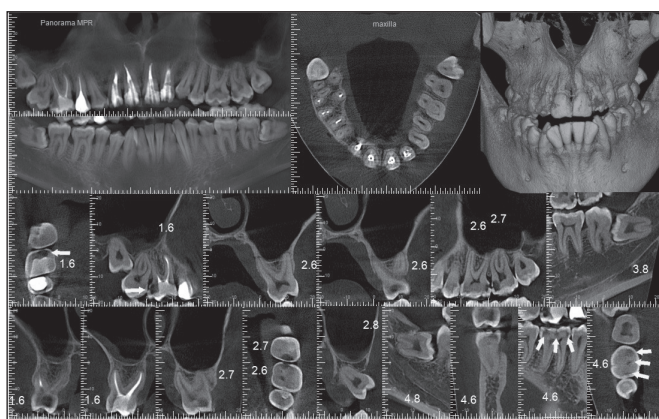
OPG and CBCT screenshots of a patient H. Hidden carious cavities in teeth 2.6 (K3), 2.7 (K4), 4.6 (K2, K3), 4.8 (K1)
